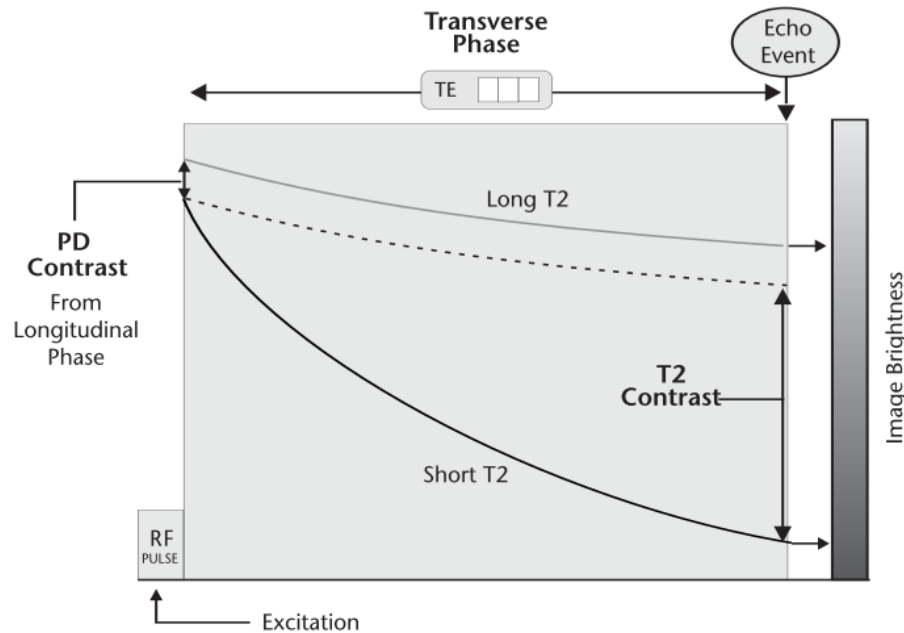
T2 weighted MRI imaging. Taken from Sprawls.⁴⁶
